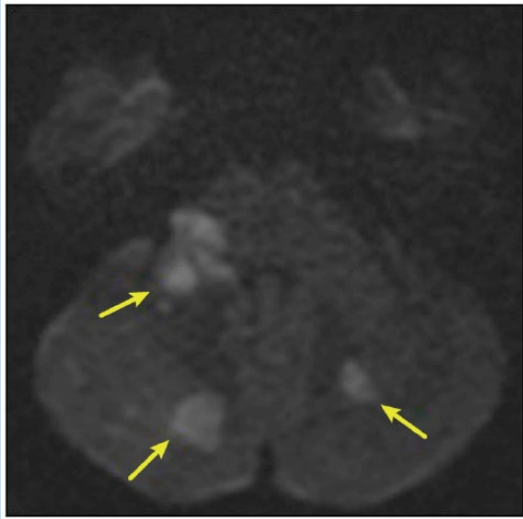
Axial diffusion-weighted image (DWI) demonstrating focal areas of restricted diffusion in both cerebellar lobes, compatible with acute infarcts.
